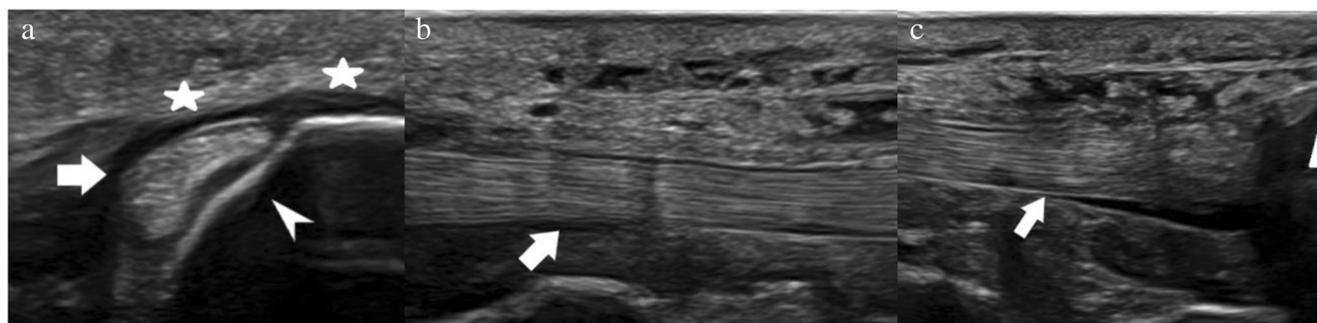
Normal sonographic appearance of the posterior tibial tendon (PTT) in a 39-year-old man. a Short-axis sonographic image of the PTT (*arrow*) at the level of the medial malleolus in the retromalleolar groove (*arrowhead*) demonstrates the normal uniform echogenic appearance. Superficial to the PTT, the flexor retinaculum (*stars*) is seen attaching to the tibia and appearing uniformly thin and hypoechoic. b Long-axis
